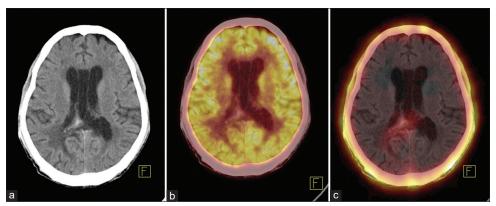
(a) Axial noncontrast computed tomography (CT). (b) fused F-18 fluorodeoxyglucose positron emission tomography (FDG PET) CT and (c) Tc-99 m GHA fused single photon emission CT showing mild FDG avid and GHA avid well-defined intra-axial isodense lesion in the splenium of the right corpus callosum with foci of calcifications within and surrounding perilesional edema. Suggestive of residual lymphomatous lesion
